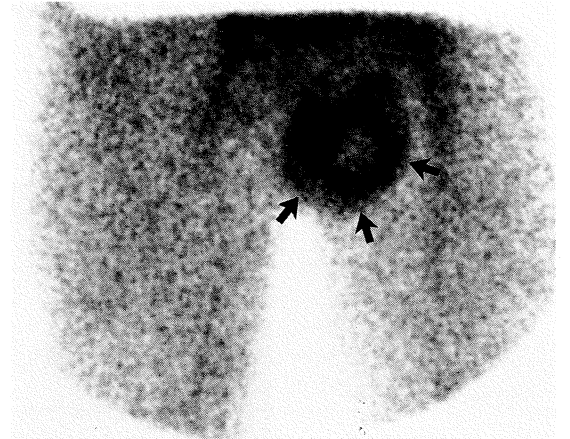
Testicular scintigraphy, static image, shows the normal right testis and a cold area in the left testis with surrounding increased uptake producing the "rim sign" or "doughnut sign" (arrows).
